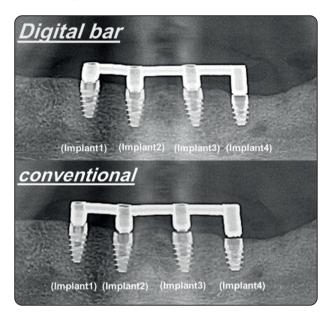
Panorama radiograph
